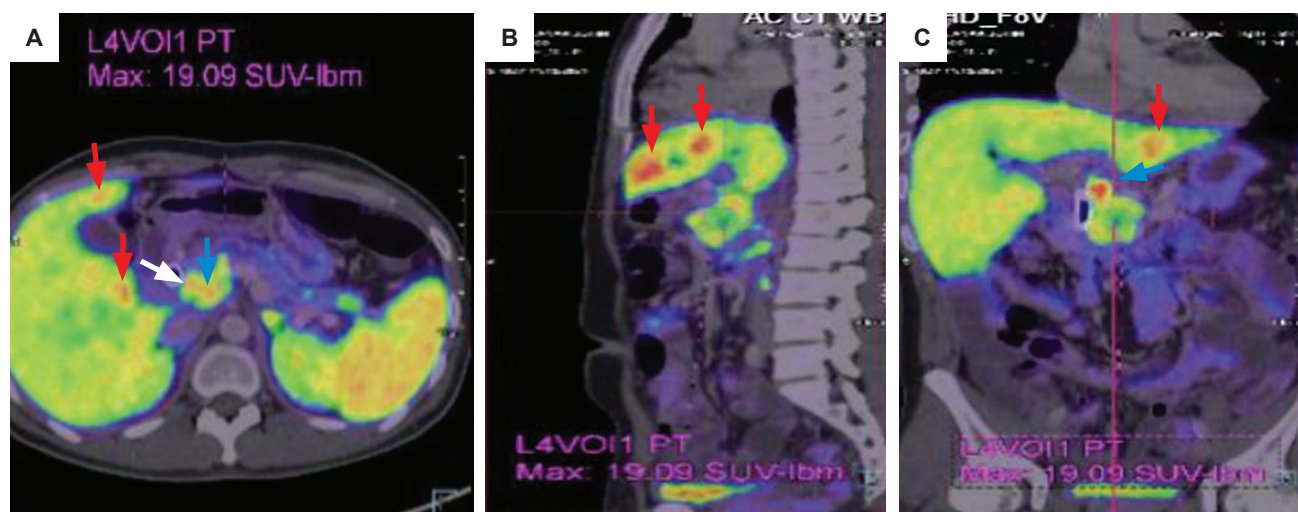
Gallium-68 DOTATATE PET-CT images show somatostatin receptor-expressing lesions: (A) adjacent porta hepatis lymph nodes (*white arrows*); (A, B and C) multiple lesions in both hepatic lobes (*red arrows*); and (A and C) a large focal lesion in the pancreatic head (*blue arrow*).
